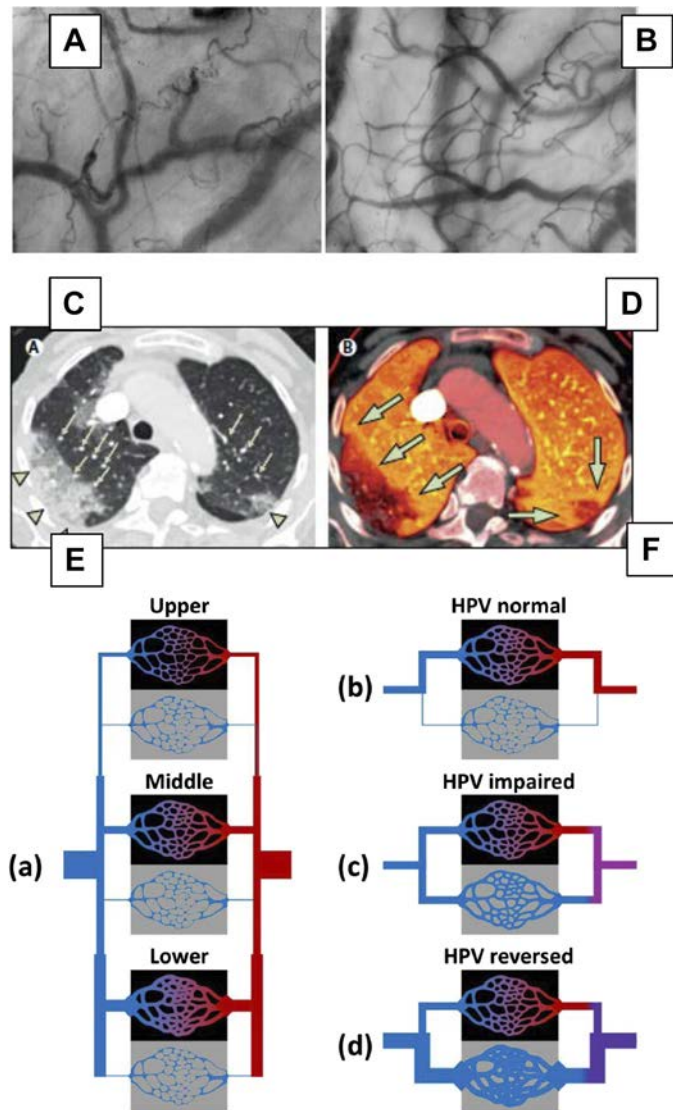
COVID-19 impact on systemic and pulmonary perfusion. A: reduced systemic microvessel density (sublingual) in a patient with a high circulating level of the fibrin degradation product known as D-dimer (6367 ng/mL $\text{PaO}_2/\text{FI}_{\text{O}_2} = 74$). B: sublingual perfusion density was markedly increased in a patient with a lower D-dimer level (741 ng/dL, $\text{PaO}_2/\text{FI}_{\text{O}_2} = 247$) (76). C: dual-energy CT showing a large dependent area of lung collapse (arrow heads), which is accompanied by dilated pulmonary vessels near and within areas of lung collapse (arrows) in a patient with SARS-CoV-2. D: in the same patient, there was a large increase in blood flow (hyperperfusion) into and around the areas of collapsed lung [arrows, dark orange (28)]. E: computational model of aerated lung (black box) and nonaerated lung (grey box) at the top, middle, and bottom of the lung (a). The amount of perfusion is depicted by the diameter of the capillary bed. F: the perfusion pattern with normal HPV (b), impaired HPV (c), and reversed HPV (d). With normal HPV, the perfusion is greater in the aerated than the nonaerated lung tissue; with impaired HPV, the perfusion is equal; and with reversed HPV, the perfusion is highest in the nonaerated tissue (80). Figure 2, A, B, E, and F, reproduced from Refs. (76) and (80) under Creative Commons License 4.0. Figure 2, C and D, reproduced with permission from Ref. (28) under license 4945480646537. FI_{O_2} , inspiratory fraction of oxygen; PaO_2 , arterial partial pressure of oxygen.
